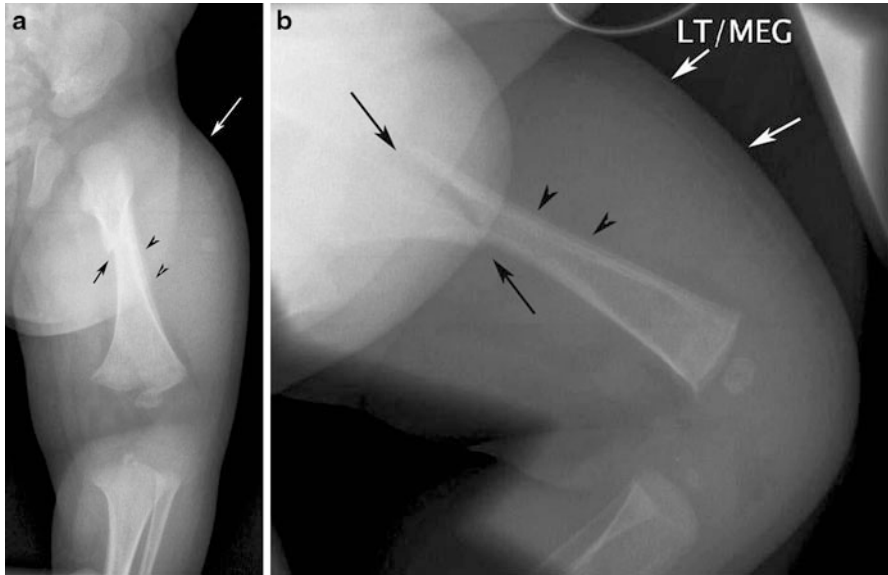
(a) and (b) Frontal and lateral radiographs of the left femur showing an oblique fracture in the proximal diaphysis (*black arrows*) with subperiosteal new bone formation (*arrowheads*) and extensive soft tissue swelling (*white arrows*) indicative of soft tissue hematoma
